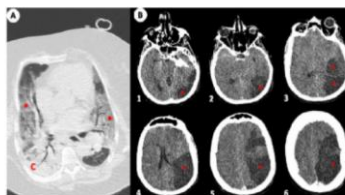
A) Lung computed tomographic imaging shown extensive areas of diffuse ground-glass attenuation (asterisks) related to basal and posterior consolidation process (C). B) Brain computed tomographic imaging evidenced an extensive hypodense injury (asterisk) involving the left cerebral and cerebellar hemispheres (1-6), inferring an area of subacute ischemic vascular injury, and edema in the left cerebral hemisphere, with a compressive effect and midline deviation
